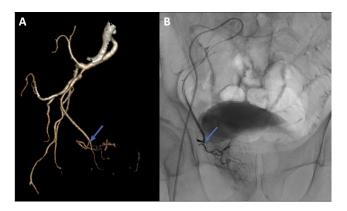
(A) Right prostatic artery (arrow) on 3D reconstruction of an abdominopelvic CTA and the right prostatic artery originates from the right pudendal artery; (B) Selective angiography image of right prostatic artery before embolization (arrow).
